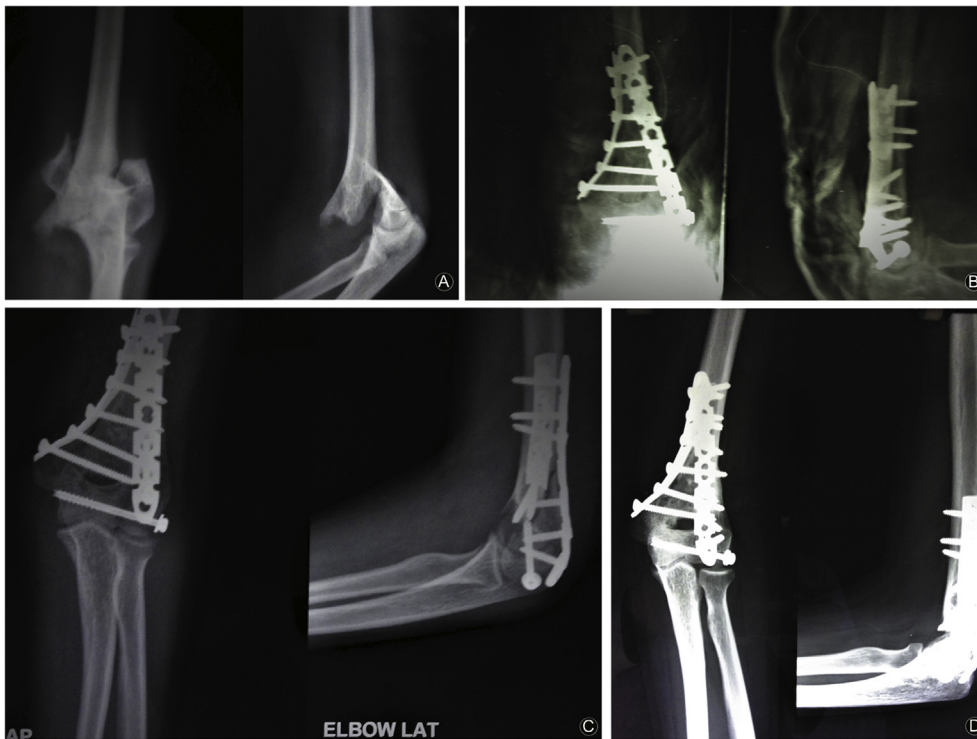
(A, B) preoperative and immediate postoperative X-rays of type C2 fracture; (C) 1 month after surgery; (D) union of fracture site at 3 month follow-up.
